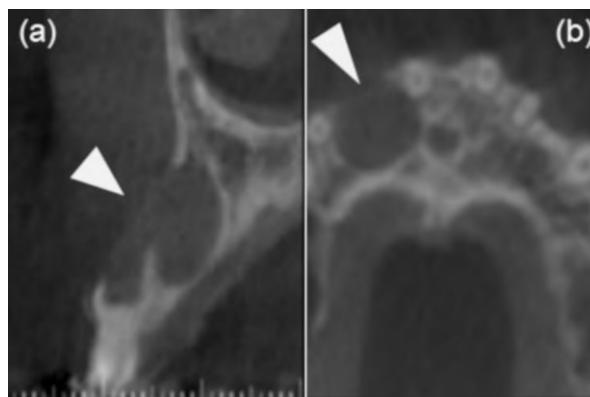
Radiographic image of a dens invaginatus Type III with extensive periradicular lesion in tooth 12.
